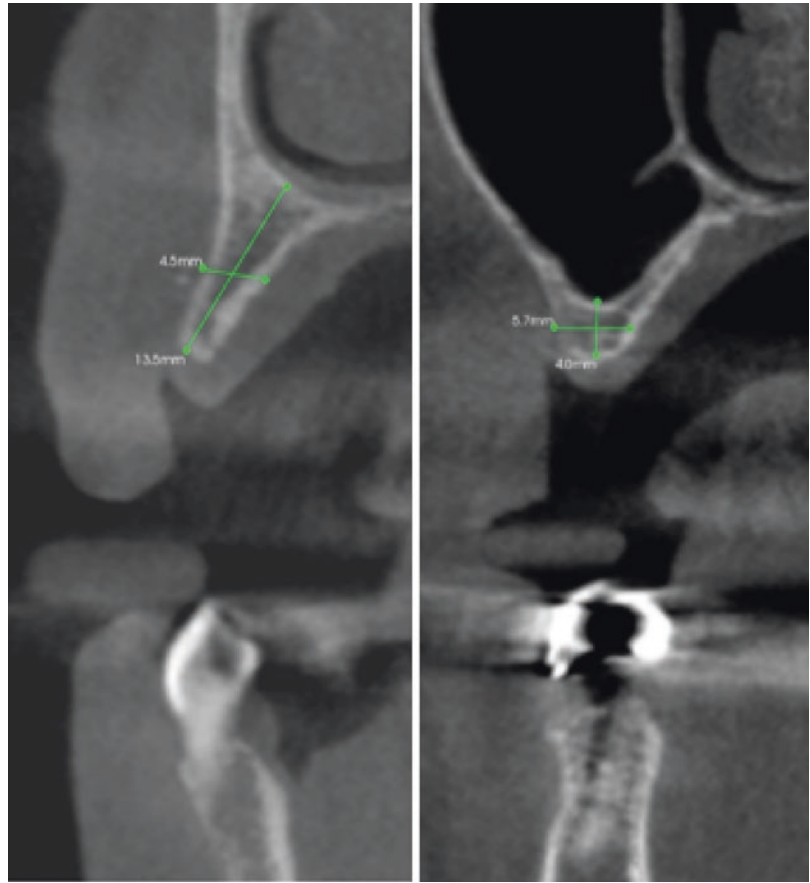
CBCT of implant case #1
